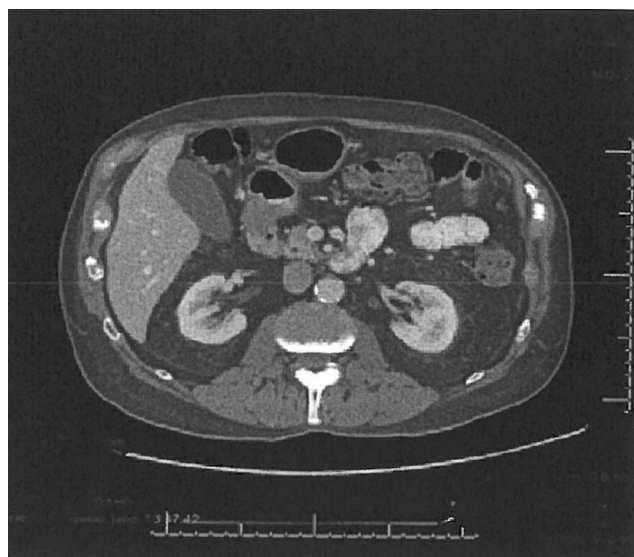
Case 1: most recent CT scan.
